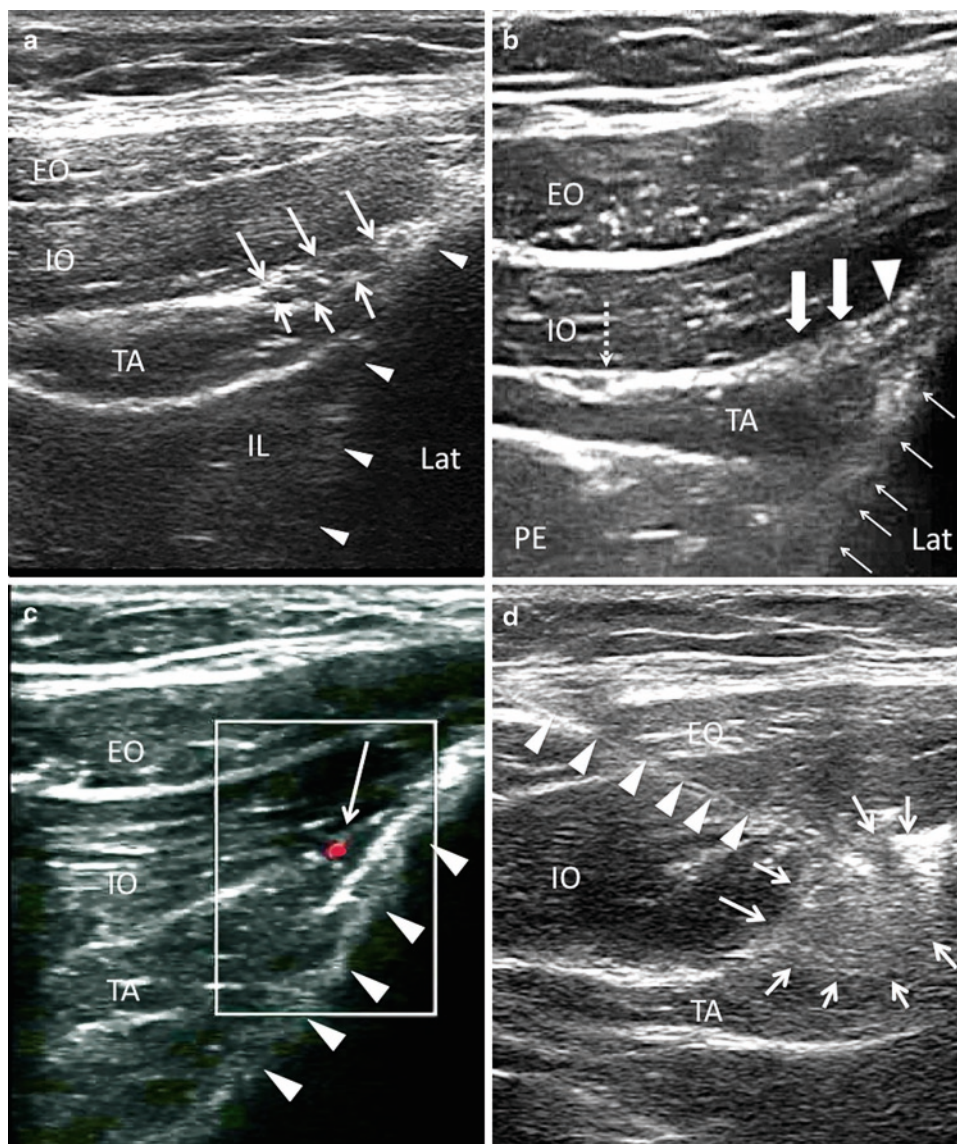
(a) Figure showing the three layers of muscles and the fascia split with the ilioinguinal and iliohypogastric nerves inside. *Solid triangles* outline the iliac crest. (b) Similar view as (a). *Solid arrows* show the ilioinguinal nerve (lateral) and iliohypogastric nerve (medial). *Solid triangle* shows the deep circumflex iliac artery. *Dashed line arrows* point to the fascia split with subcostal nerve (T12). Usually the fascia split for ilioinguinal and iliohypogastric nerves appears adjacent to the iliac crest. When it appears far away from the iliac crest like the one in this figure, one should suspect subcostal nerve. *Solid line arrows* outline the iliac crest. (c) Similar view as (b) with color Doppler. The deep circumflex iliac artery is shown in *red color*. *Line arrows* outline the iliac crest. (d) Figure showing the needle (outlined by *solid triangle*) inserted with in-plane technique and the *line arrows* outline the spread of the local anesthetic and steroid solution. EO external oblique muscle, IO internal oblique muscle, TA transverse abdominis muscle, IL iliacus, PE peritoneum, LAT lateral. Reproduced with permission from USRA (www.usra.ca).
